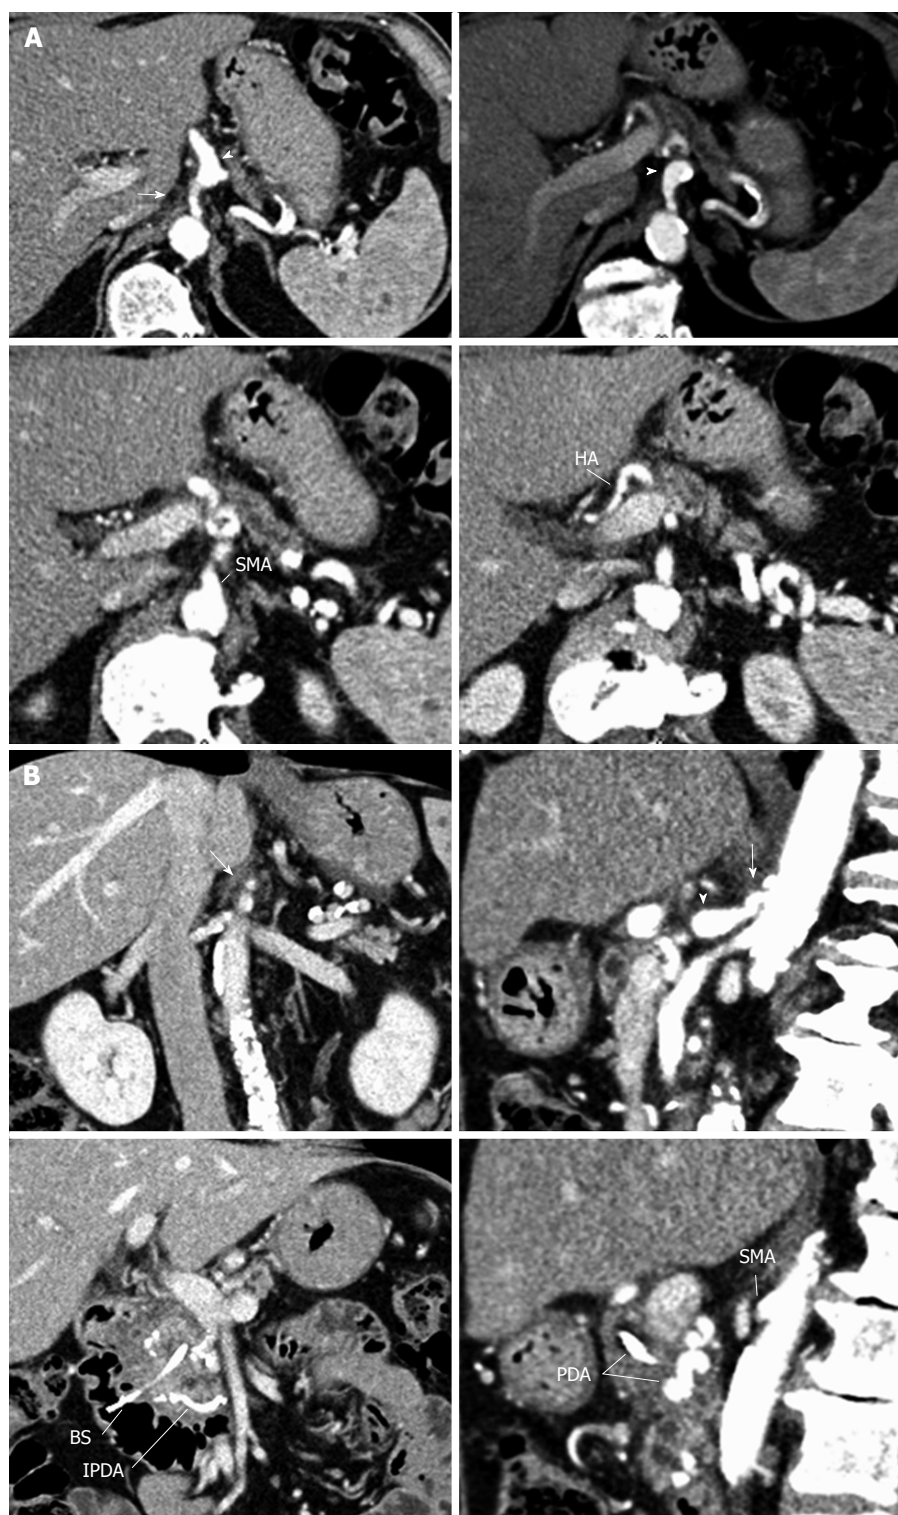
Features of median arcuate ligament. Arterial phase of the axial computerized tomography (CT) scan (A), along with coronal and sagittal CT-scan reconstructions (B) showing severe stenosis of the celiac trunk from extrinsic compression by dense fibrous tissue (arrow) and poststenotic dilation of the proximal celiac trunk (arrowhead). SMA: Superior mesenteric artery; HA: Hepatic artery; PDA: Pancreaticoduodenal arcade; IPDA: Inferior pancreaticoduodenal artery; BS: Biliary stent.
